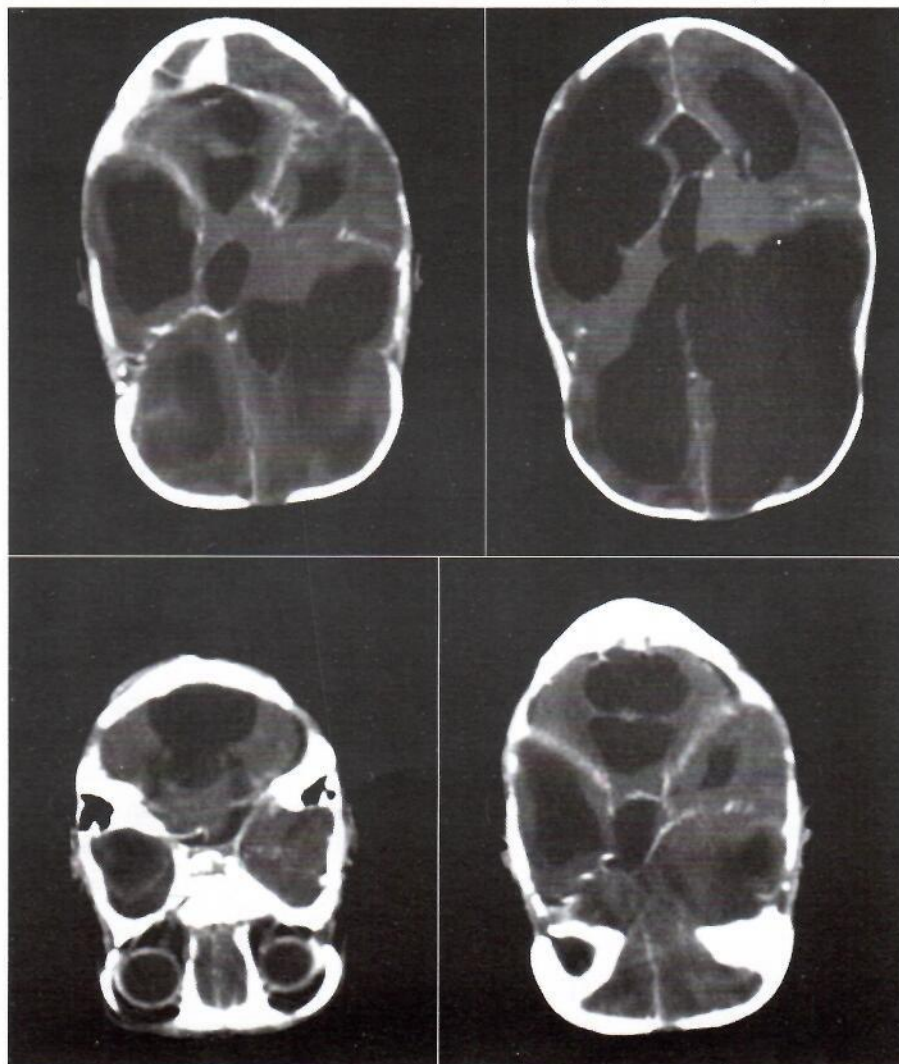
Contrast enhanced axial CT images showing the posterior fossa
